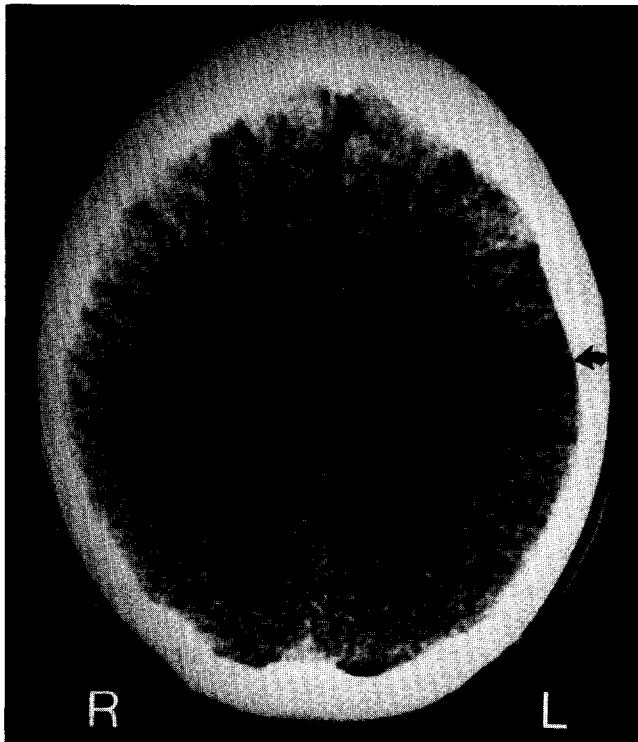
CT transverse section of the brain showing a region of low attenuation in the high left parietal lobe (arrow) representing the left parietal infarction. The small left centrum semiovale lacunar infarct is seen just medial to the cortical infarct.
